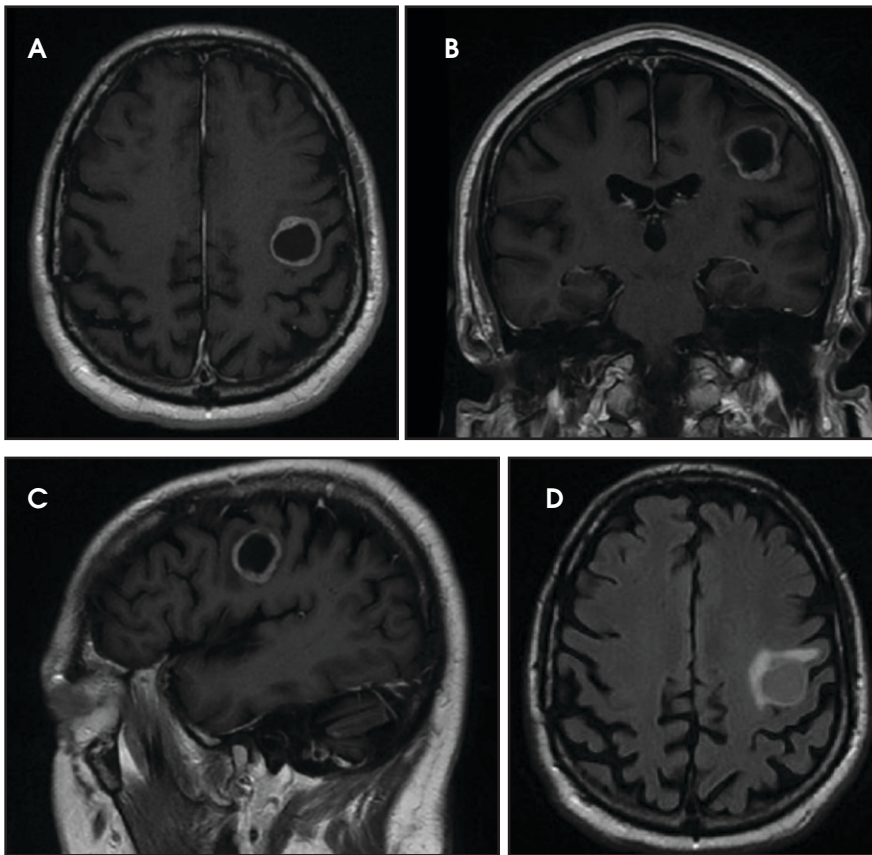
Representative T1 MRI images with intraluminal contrast completed prior to resection in the (A) transverse, (B) coronal, and (C) sagittal views depicting a rounded peripherally enhancing juxtacortical mass centered within/along the anterior left precentral gyrus at the level of the centrum semiovale with areas of more discrete nodular enhancement along its anterior and inferolateral margins. (D) FLAIR MRI image with intraluminal contrast completed prior to resection, depicting mild surrounding vasogenic edema with no midline shift or significant mass effect.
